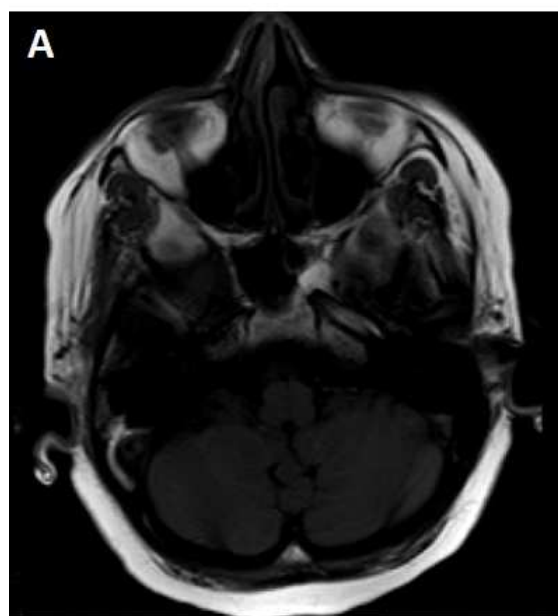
Brain MRI of the patient revealed no any lesions after 1-year follow-up. A: T1-weighted without contrast; B: T1-weighted with intravenous contrast; C: T2-weighted; D: T2-weighted FLAIR sequence
